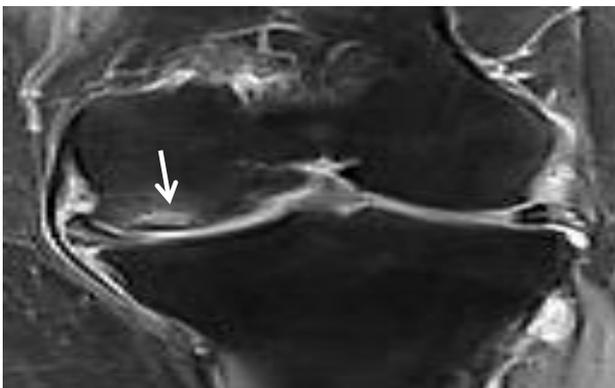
Subchondral marrow edema in medial femoral condyle. Coronal T2-weighted FSE fat-suppressed image shows linear subchondral marrow edema (arrow) associated with an adjacent medial meniscal tear.
